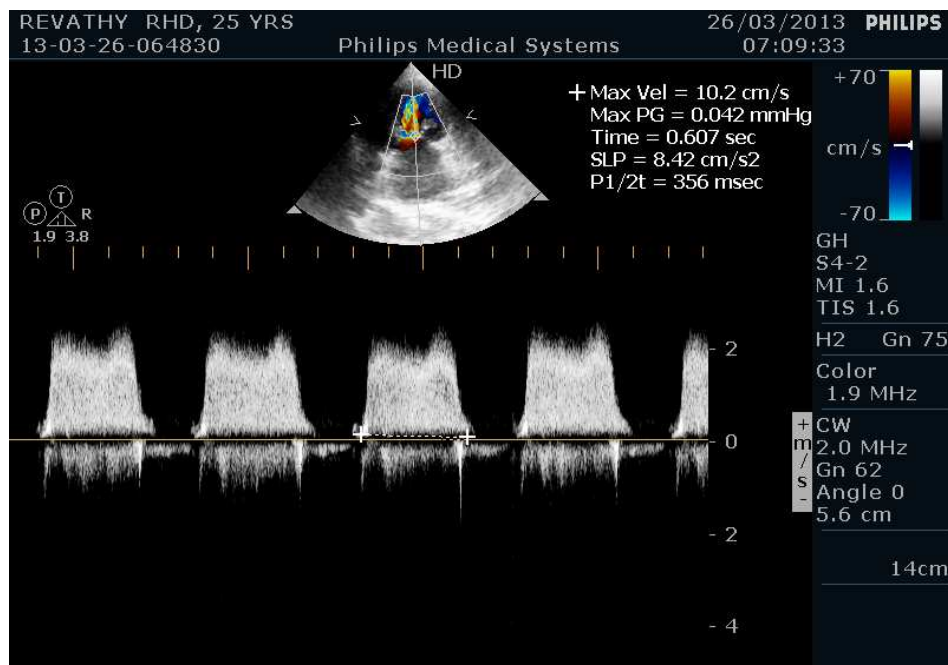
diastolic filling period in mitral stenosis by echocardiography.
